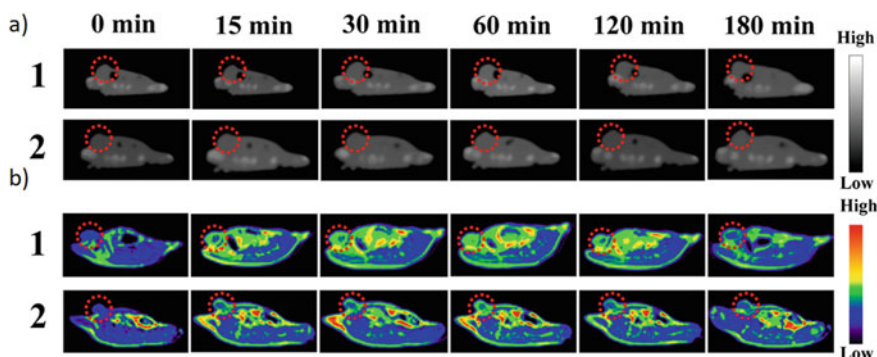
a CT images and b T1-weighted MR image of Gd@Au CSTDs in vivo. Reproduced with permission from Ref. [43] Copyright 2021, with permission from ACS
